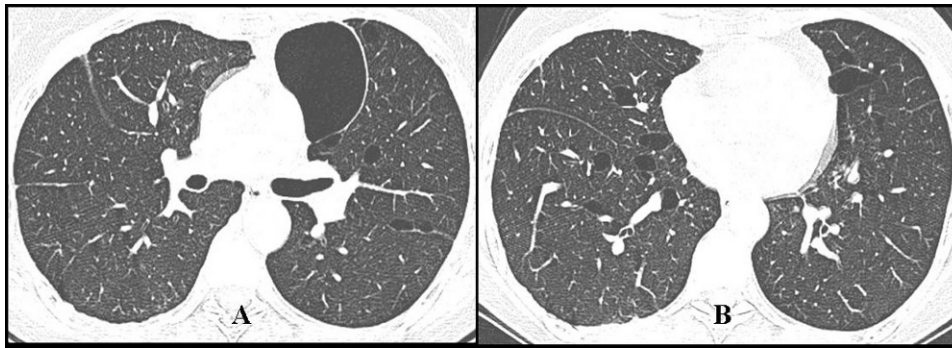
High-resolution chest CT. A) A CT scan showing thin-walled, air-filled cystic lesions, including one dominant cyst (6×5 cm). B) In addition to the cystic lesions, posterior pleural thickening due to previous pleurodesis is observed on the right side.
